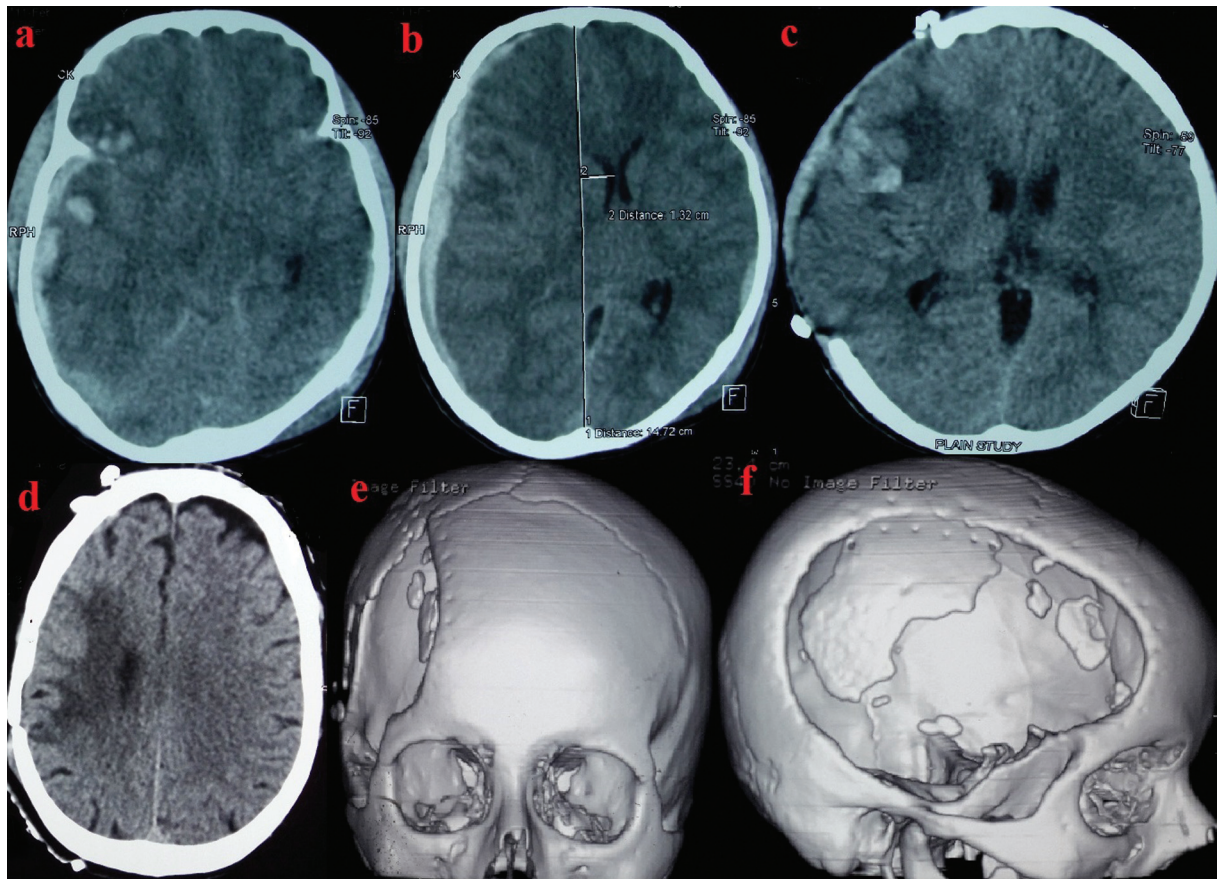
Preoperative CT scans (A, B) showing a right-sided acute subdural hematoma with contusions causing mass effect and midline shift; post DC CT image (C) showing decrease of mass effect; immediate post CP image (D) showing replaced bone flap and 3D reconstructed CT scan images after 2 years (E, F) showing significant resorption of the bone flap with only patchy islands remaining intact.
